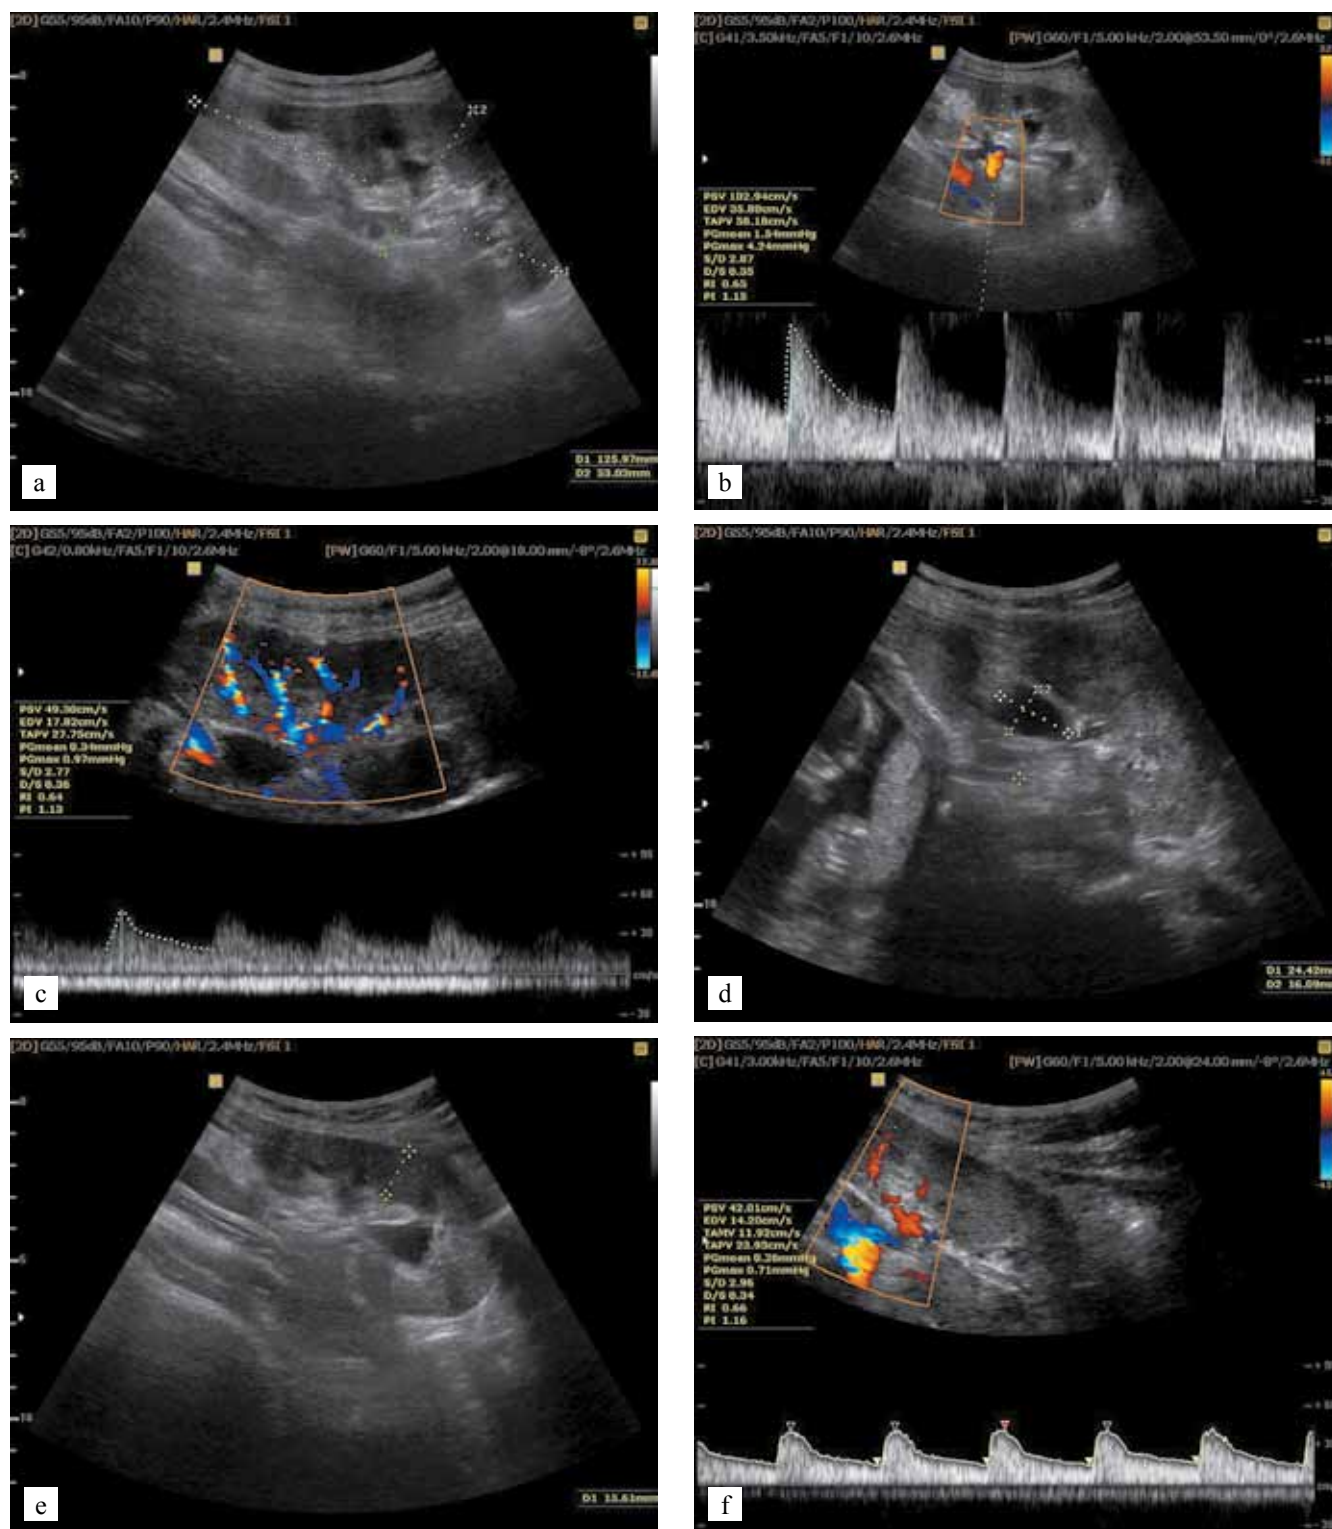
Ultrasonic characteristics of transplanted complex on day 8 of the postpartum period. Transabdominal ultrasound with a 3.5–5 MHz transducer in the “abdomen” menu: 1–3 – ultrasound image of the renal graft: a – B-mode, b – Doppler ultrasound of blood flow in the main trunk of the graft renal artery, c – in the interlobar arteries of the renal graft; d–f – ultrasound image of the liver transplant gate structures: d – *vena portae*, B-mode, e – reno-portal anastomosis, B-mode, f – Doppler ultrasound of blood flow in *vena portae* and reno-portal anastomosis
